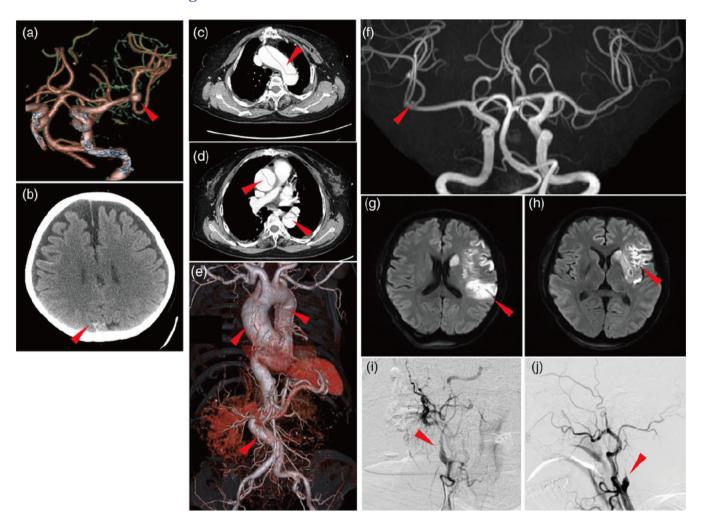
Radiographic findings of three patients with vascular complications. (a—e, patient #1) A brain enhanced computed tomography (CT)-based angiography (a) shows a left inner carotid artery aneurysm (arrowhead). A brain CT reveals an occipital subarachnoid hemorrhage (b). Chest CT images (c, d) and chest to abdominal CT-based angiography (e) show an extensive aortic dissection from the ascending aorta, aortic arch, and descending thoracic to abdominal aorta (arrowheads). (f, patient #7) A magnetic resonance imaging (MR)-based angiography shows a right inner carotid artery aneurysm of 2 mm in diameter (f). (g—j, patient #23) A diffusion-weighed brain MR imaging (g, h) shows a high intensity area in the left middle cerebral artery region. A digital subtraction angiography shows stenotic lesions (arrowheads) of the right (i) and left (j) inner carotid arteries
